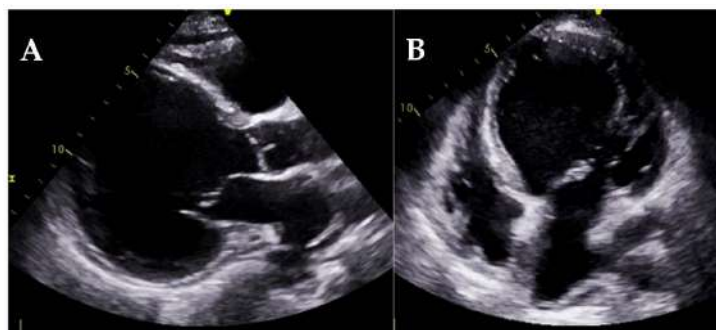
Transthoracic echocardiography of a patient with dilated cardiomyopathy, showing a parasternal long-axis view (A) and an apical 4-chambers view (B). Note the marked dilatation of the left ventricle and the spherical pattern.
